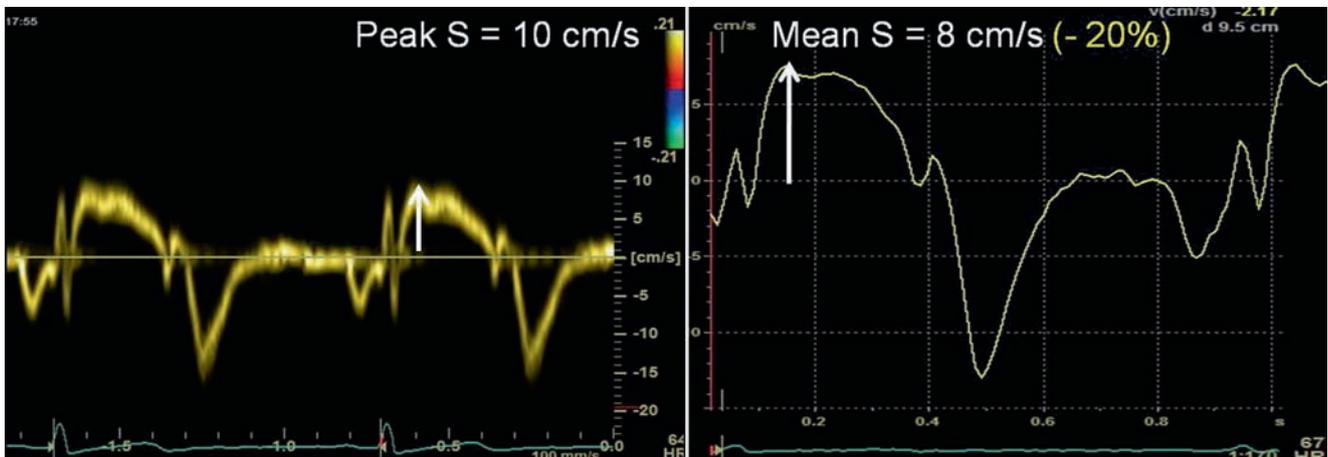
Basal septal Doppler tracings from a normal subject recorded using pulsed-wave TVI (*left panel*) and colour Doppler TVI (*right panel*). Pulsed Doppler peak systolic myocardial velocities (*S*) are about 20% higher than mean velocities recorded by colour Doppler
